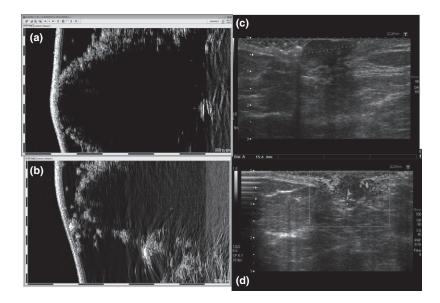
(a) High resolution dermatologic Ultrasound showing the right nipple compared to the left nipple (b). Ultrasound shows a hipoechoic area (c) and (d) Doppler shows increase in vascularization.
